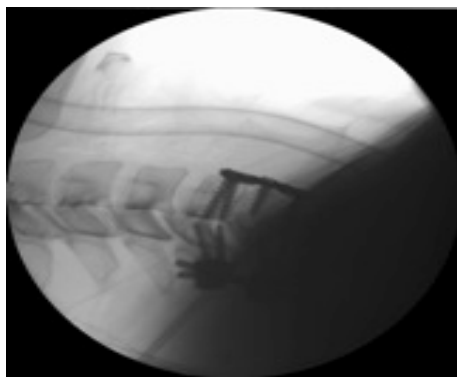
C-spine X-ray of the same patient after a frontal and posterior stabilisation surgery with metal implants was done.
